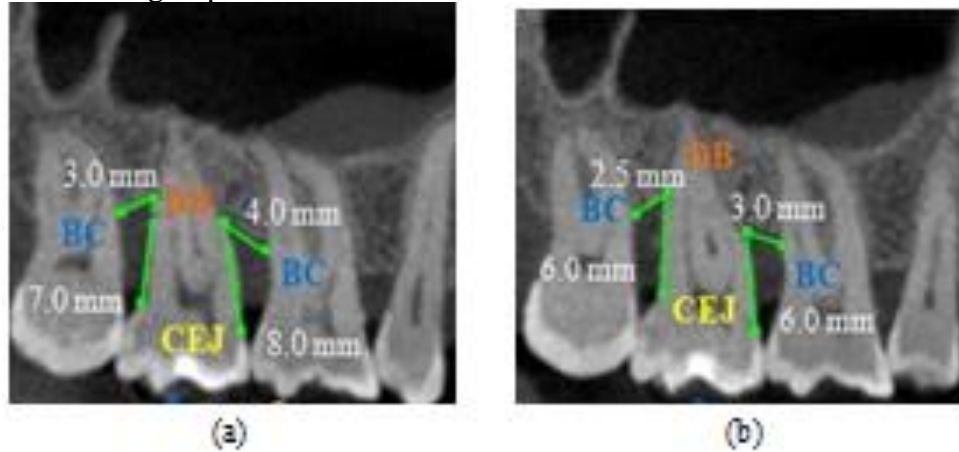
CBCT of upper right quadrant showing second molar with defect depth measures of 8.0 mm mesially & 7.0 mm distally at baseline (a) and 6.0 mm on mesial & distal root surface at 6th month post surgery (b).
